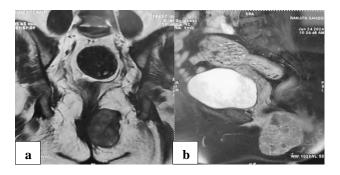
(a and b): MRI findings of the right vulval mass.
